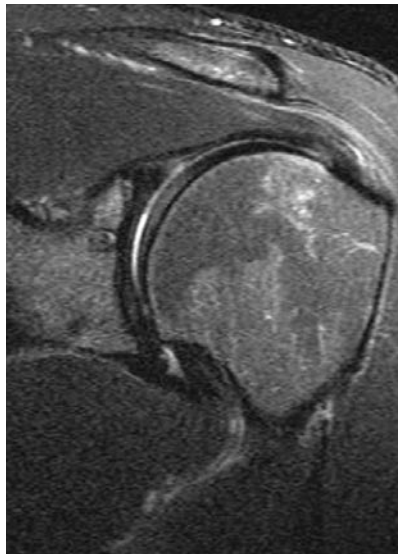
Magnetic resonance imaging 7 months after surgery shows complete cyst resolution and healing of a superior labral tear.
